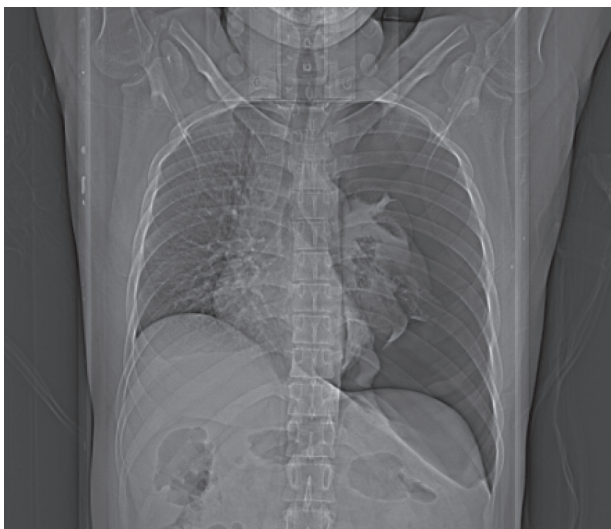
X-ray chest postero-anterior view showing pneumothorax.
